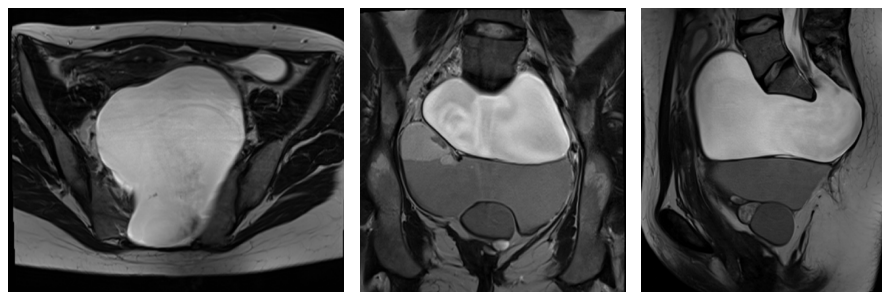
Preoperative MRI imaging, T2 sequence, showing the meningocele in three planes axial, coronal and sagittal (from left to right).
